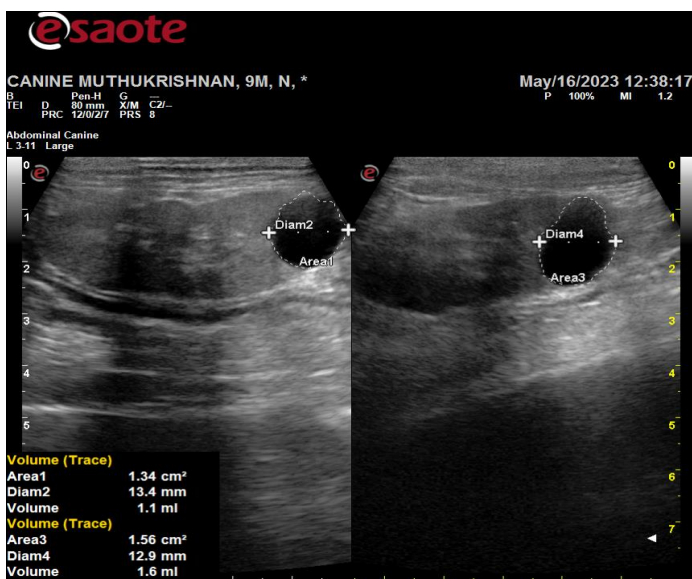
Ultrasound of kidney (Sagittal view) bilateral, single, thin walled anechoic cyst present in both kidney Fig B: CT image showed cyst attenuation in the left kidney (arrow mark)
